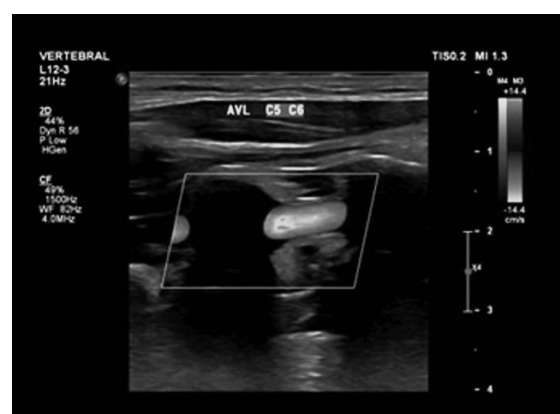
Neurovascular ultrasound showing minimal residual hematoma in left right vertebral artery
